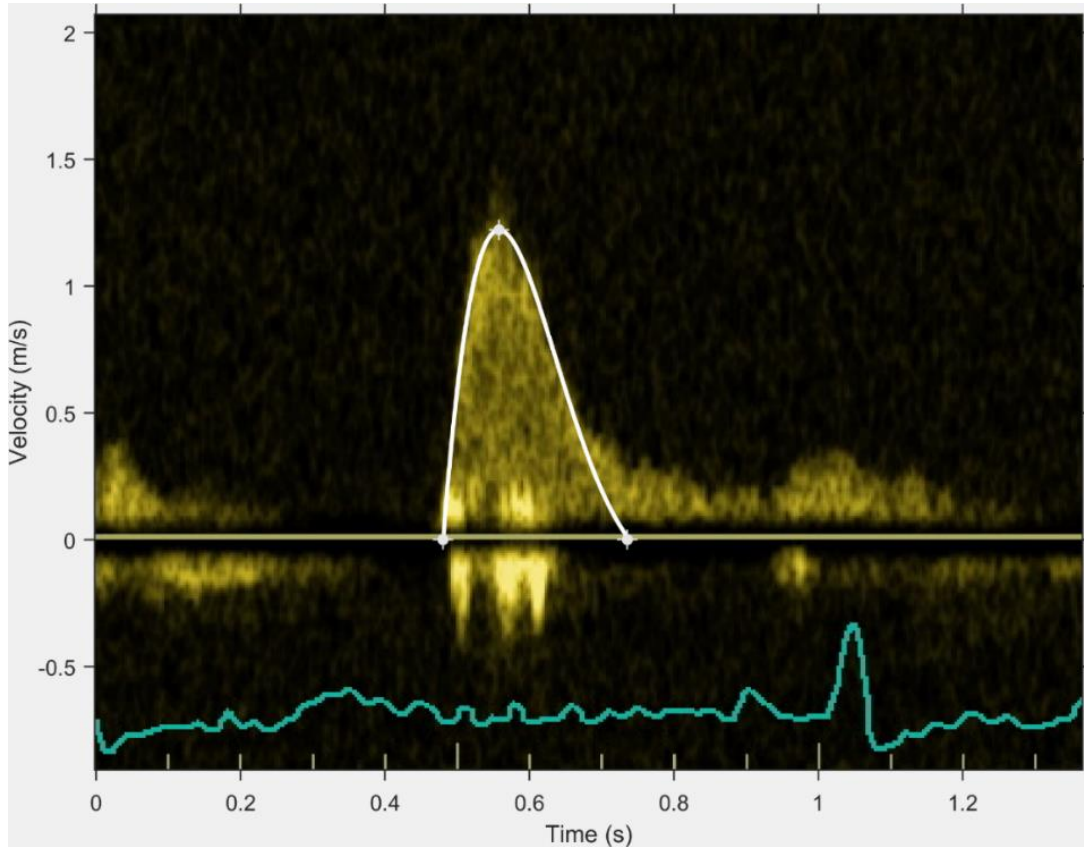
Doppler recording and PDF curve. The white curve was obtained by fitting the Doppler velocity profile to the PDF equation, yielding $c = 17.3 \text{ g/s}$, $k = 135 \text{ g/s}^2$, and $x_0 = 11.4 \text{ cm}$, and then using these constants to plot $v(t)$ on top of the original image for assessment of fit accuracy.
